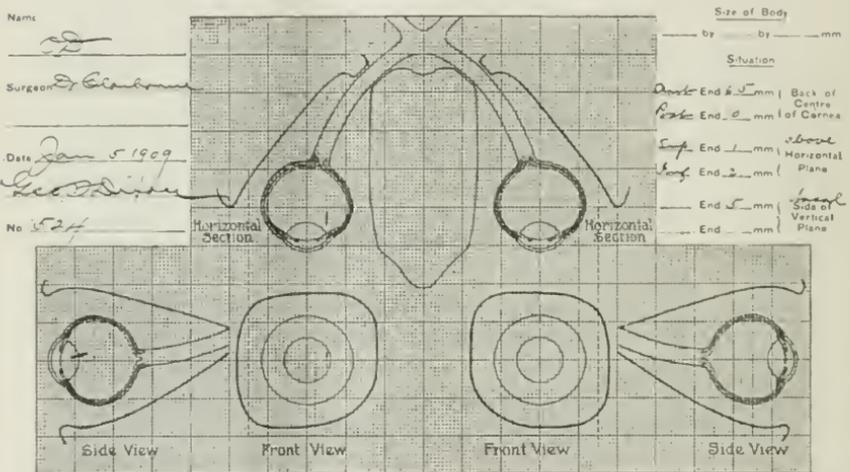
X-ray localization chart of a piece of glass in the eye; one-half size.
